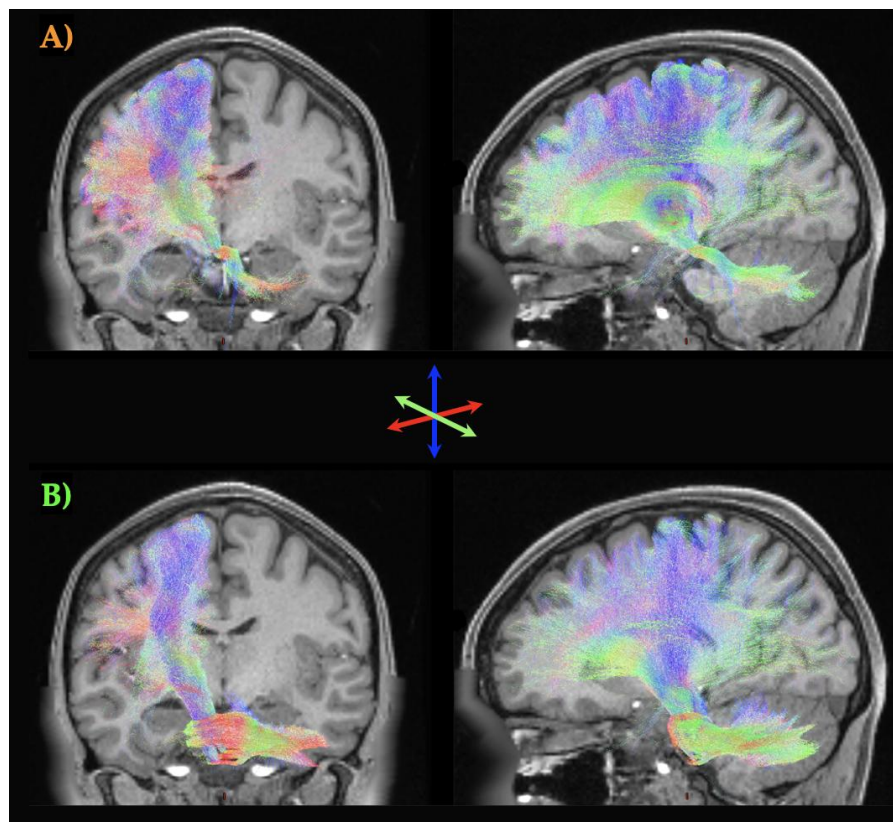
White matter streamlines interconnecting the cerebellum and the cerebral cortex. A) the Cortico-Ponto-Cerebellar (CPC) tract sends projections from the cortex via the pontine nuclei into the mossy fibres of the cerebellum; B) the Cerebello-Thalamo-Cortical (CTC) –B) tract derives from the deep cerebellar nuclei, which project back via the core thalamic nuclei to the cerebral cortex. Tracts created using *mrtrix* were projected onto a T1-weighted structural image from individual 100307 from the Human Connectome Project (de-faced to preserve
